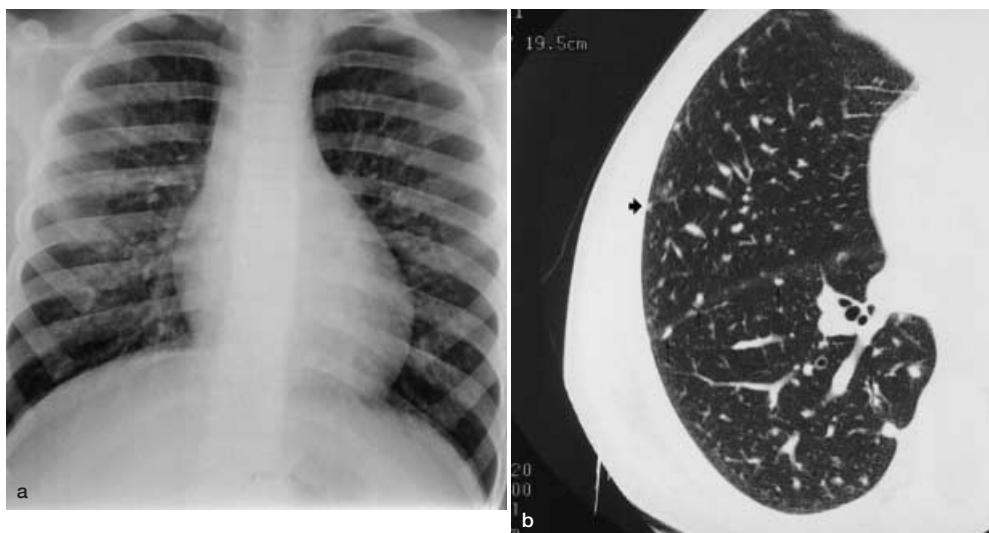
High-resolution CT section of patient no. 4, carrying a normal chest radiograph, displays few intrascissural micronodules (*arrows*) and tiny ill-defined centrilobular micronodules (*large arrows*)
